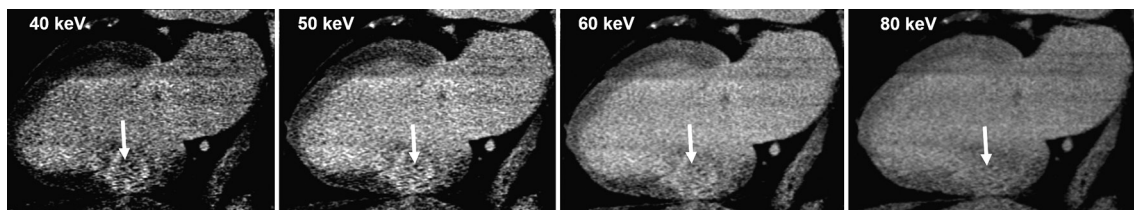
Patient with previous myocardial infarction. Long vertical axis of dual energy CT acquired 8 minutes after contrast administration. Average, 7 mm multiplanar reconstructions show transmural delayed enhancement of the inferior basal wall, more clearly depicted at the lowest energy levels (arrows).
